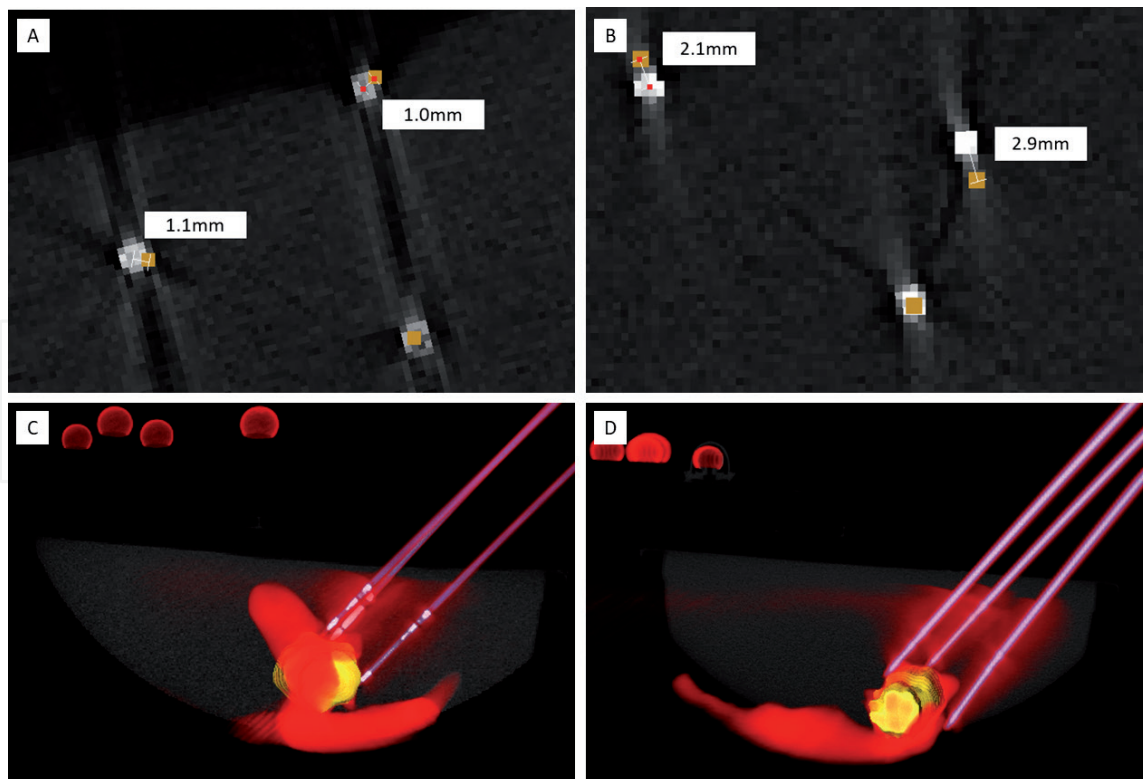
Comparison of aiming device versus freehand for a specific participant. The top row visualizes the calculation of the Euclidean error between the aiming device (A) and freehand (B) approach. Volume rendering from control CT of aiming device (C) and freehand (D) guidance highlights the bending of the needle in the freehand approach.
